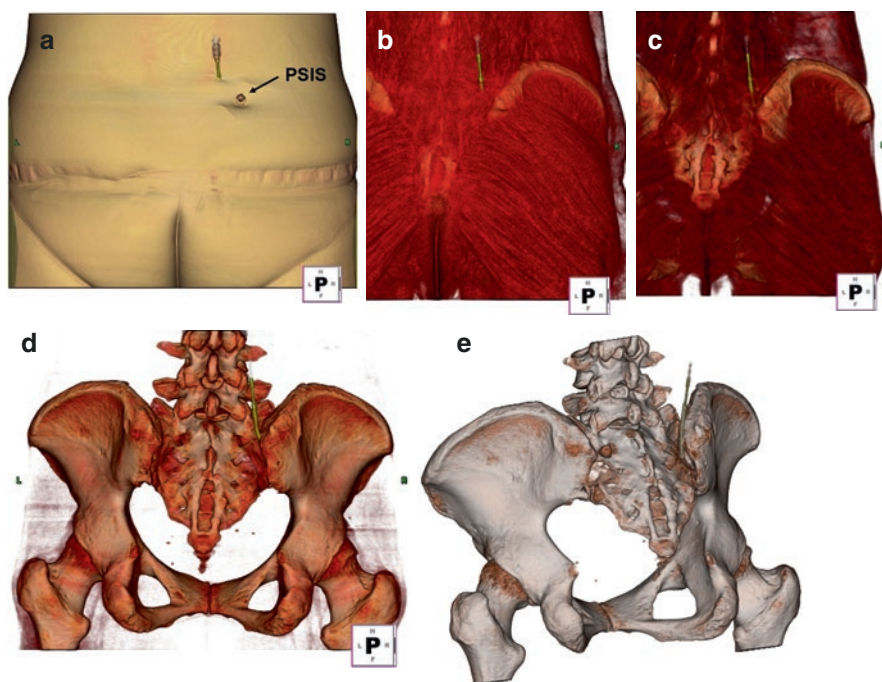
(a) The skin penetration point. (b) The site of the needle penetrating muscle. (c) The site of insertion into the interosseous sacroiliac ligament. (d) AP view on CT of the insertion into the gap between the sacrum and the inner edge of the PSIS. (e) The oblique view on CT. With permission from [7]
